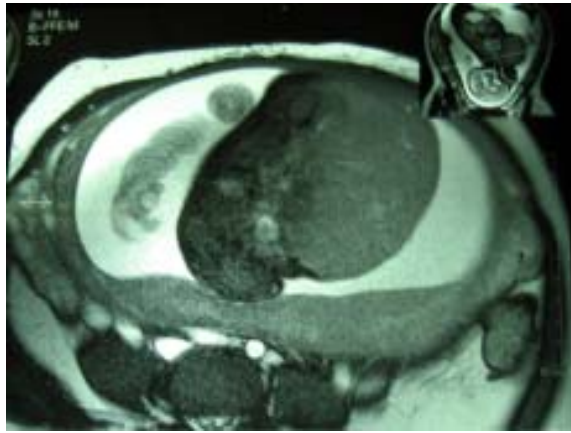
Axial cut of magnetic resonance imaging of the fetus shows a huge solid mass on the anterior portion of the neck and chest
